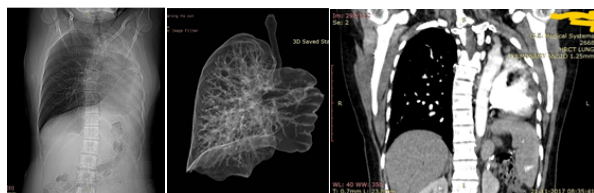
Coronal CT image and its volume rendered image showing left lung aplasia.
